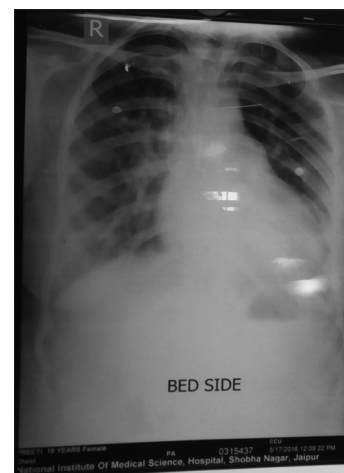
X-ray chest showing cardiomegaly and prominent broncho-vascular margins. The transthoracic echocardiography
